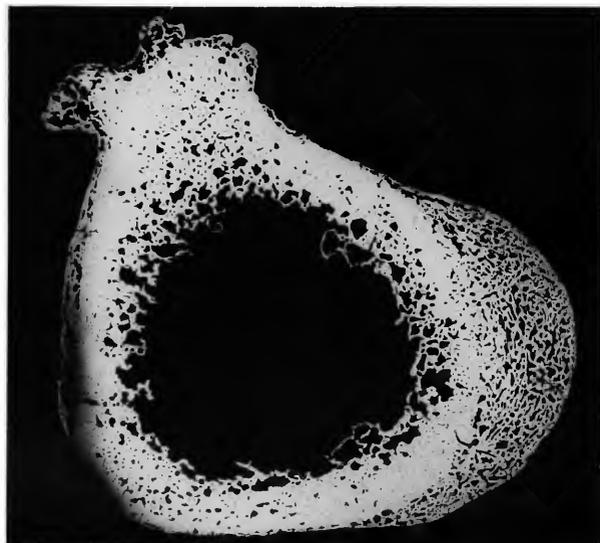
Severe fluorosis. X-ray of cross-section of femur, showing massive subperiosteal bone deposition and some intracortical resorption. (Adult Asian Indian male, courtesy Dr. Niranjana Das Aggarwal, Rajendra Hospital and Medical College, Patiala, India.)
